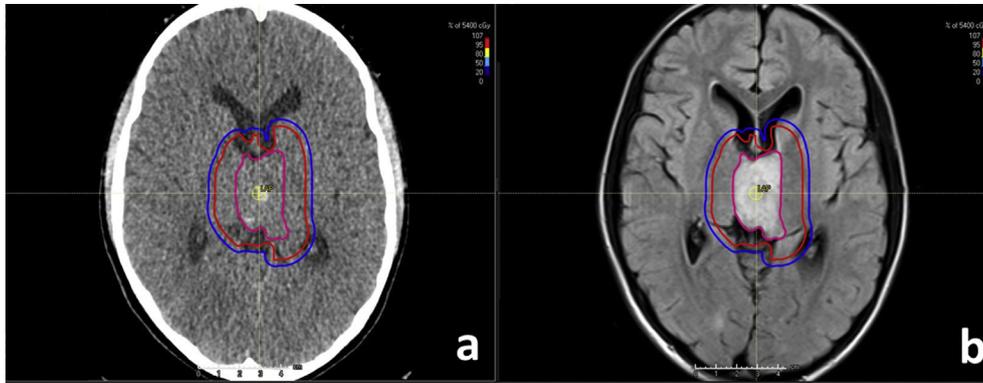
Planning computed tomography scan (a) fused with magnetic resonance image (b) for contouring of a patient with diffuse midline glioma (generated in RayStation®). The pink line corresponds to the gross tumour volume, the red line shows the clinical target volume and the blue line is the planning target volume.
